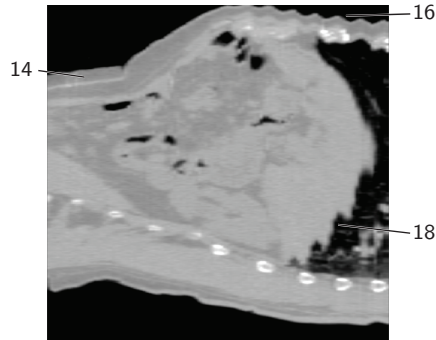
sagittal CT-slice of the patient of Fig. 6.1.*
